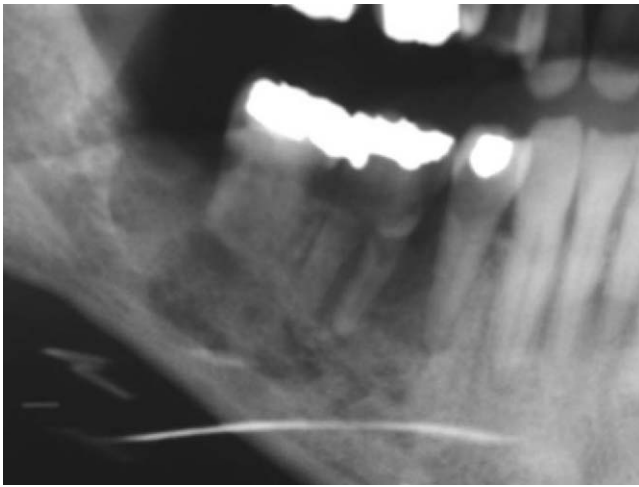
Radiographic appearance of osteoradionecrosis.
